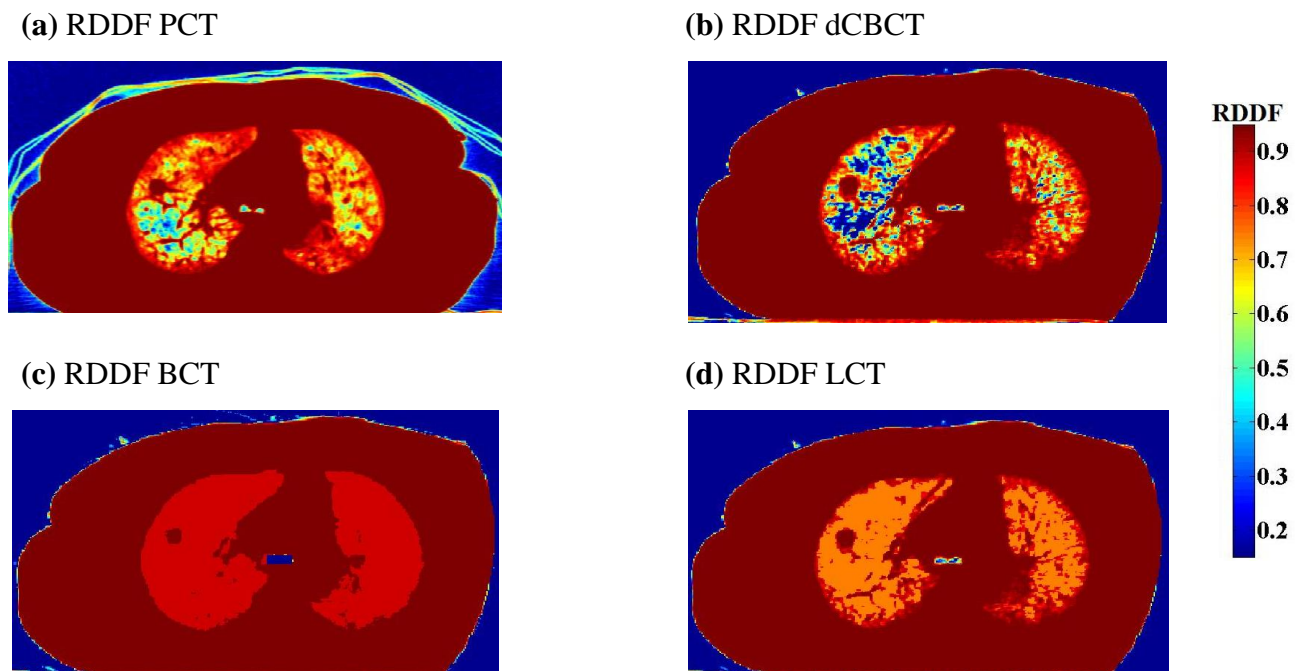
shows the Relative Depth Dose Factor (RDDF) maps acquired from the PCT, dCBCT, BCT, and LCT image sets. These maps (calculated using data from Fig. 4-2) provide regional information concerning the estimated magnitude of LED. The RDDF value quantifies the extent/severity of LED, and regions of lung tissue that are more apt to establish LED are easily identified.
